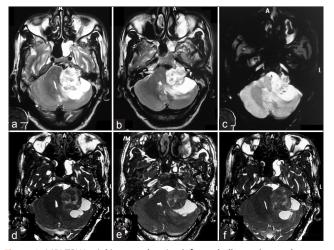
MRI T2W axial images showing left cerebellopontine angle tumor with mass effect and midline shift
